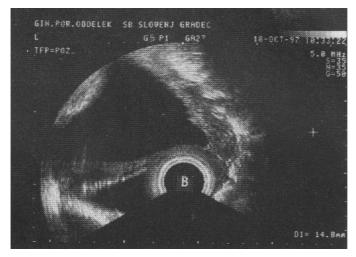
B. Measurement of cervical length by transvaginal sonography in severe shortening and marked funneling of the cervix.
